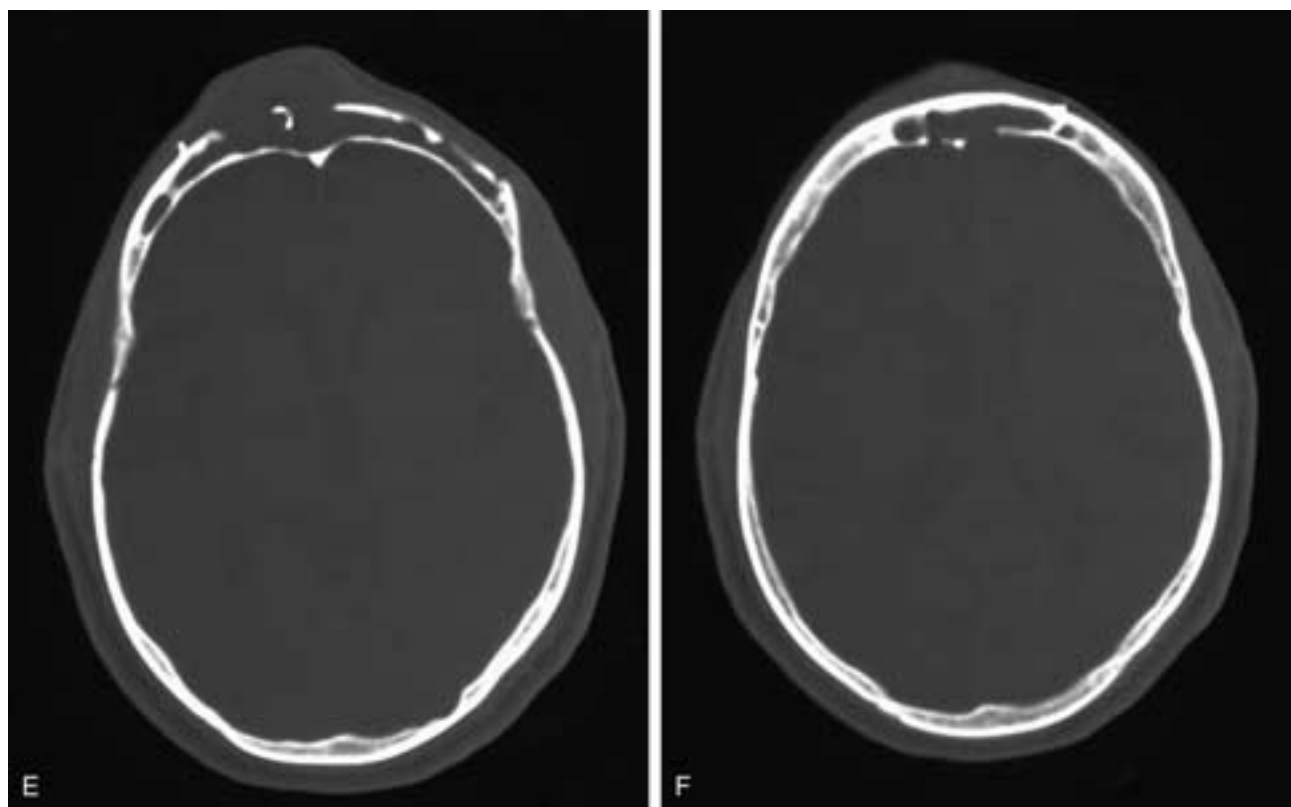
Continued.* Corresponding axial CT scans (E, F) show the bone defects.
